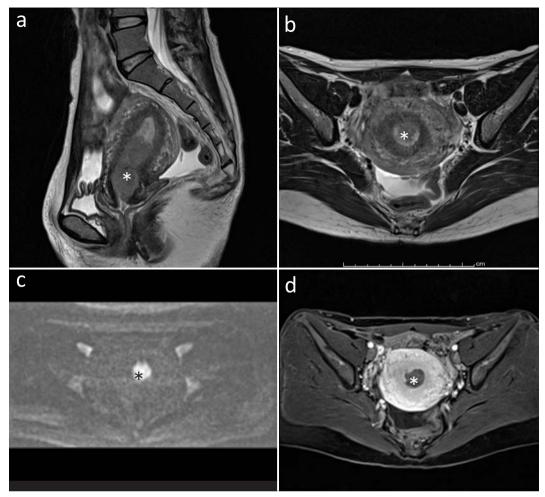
A 53-year-old woman with pT1b carcinoma (3.0 T MR images) a. T2-weighted sagittal image, b. T2-weighted axial image, c. Diffusion-weighted axial image, d. Dynamic contrast images with 3.0 T MRI; * = tumor.
